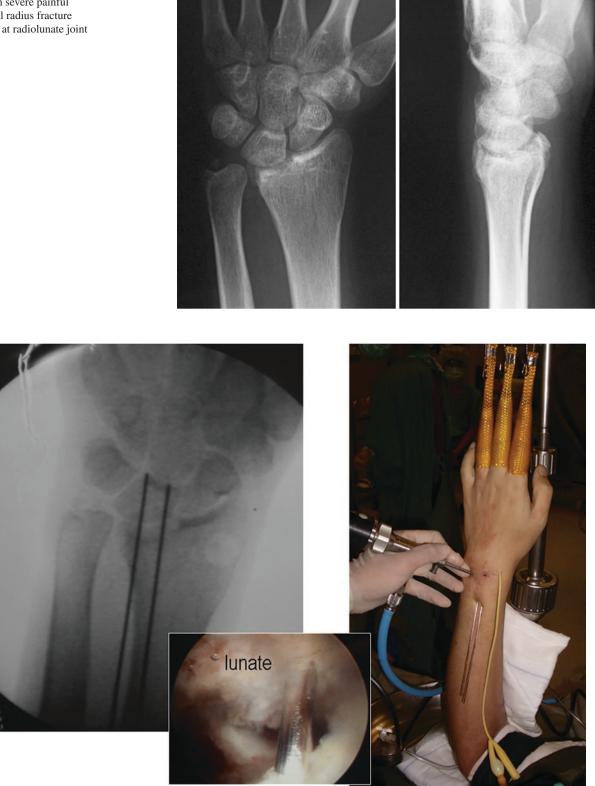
Percutaneous pinning of the radiolunate joint under X-ray and arthroscopic guidance. A Foley catheter had been placed to obliterate the space at the radioscaphoid joint
